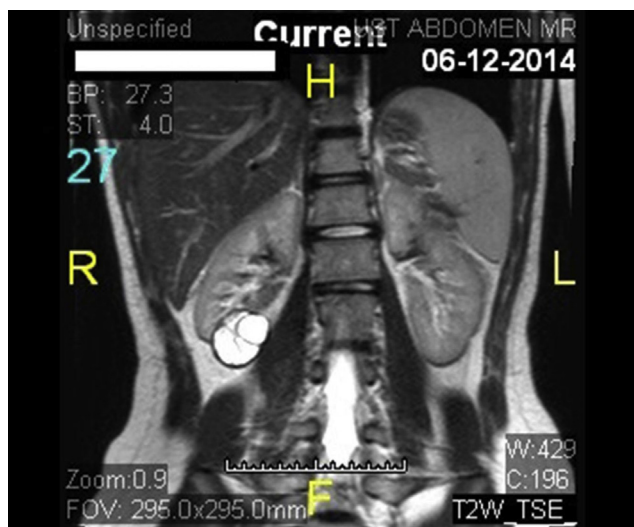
MRI showing a solitary lesion with exophytic extensions containing large septations.
